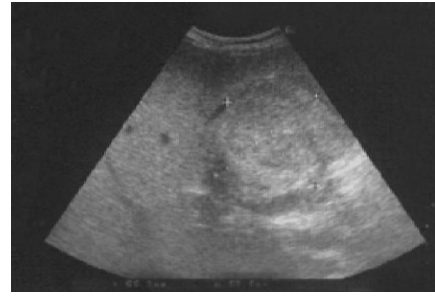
Solid tumor in the fourth segment of the right lobe of the liver (abdominal ultrasound).
